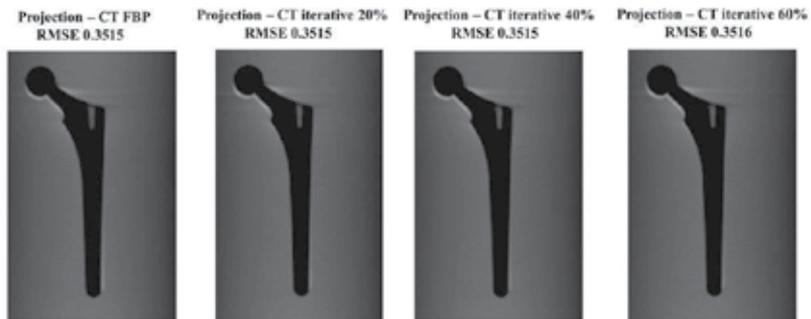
Comparison between CT error images and RMSE of images obtained from conventional FBP and iterative reconstruction algorithms in the in-focus plane. (Reference is the projected image.)
